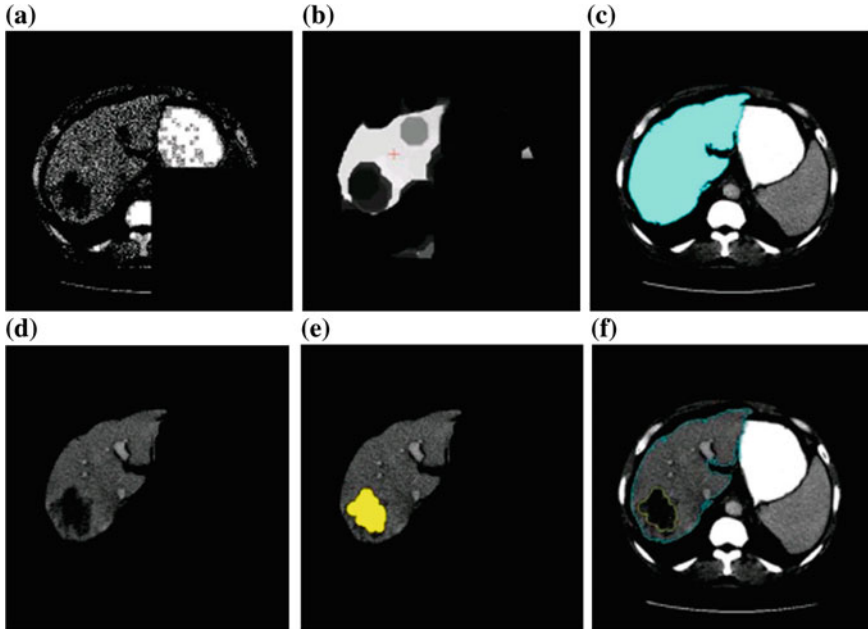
CT liver image segmentation: a Simplified image, b Eroded image with centroid, c Region grown liver, d Segmented liver, e Segmented tumor using the AFCM approach, and f Segmented liver and tumor [31]
